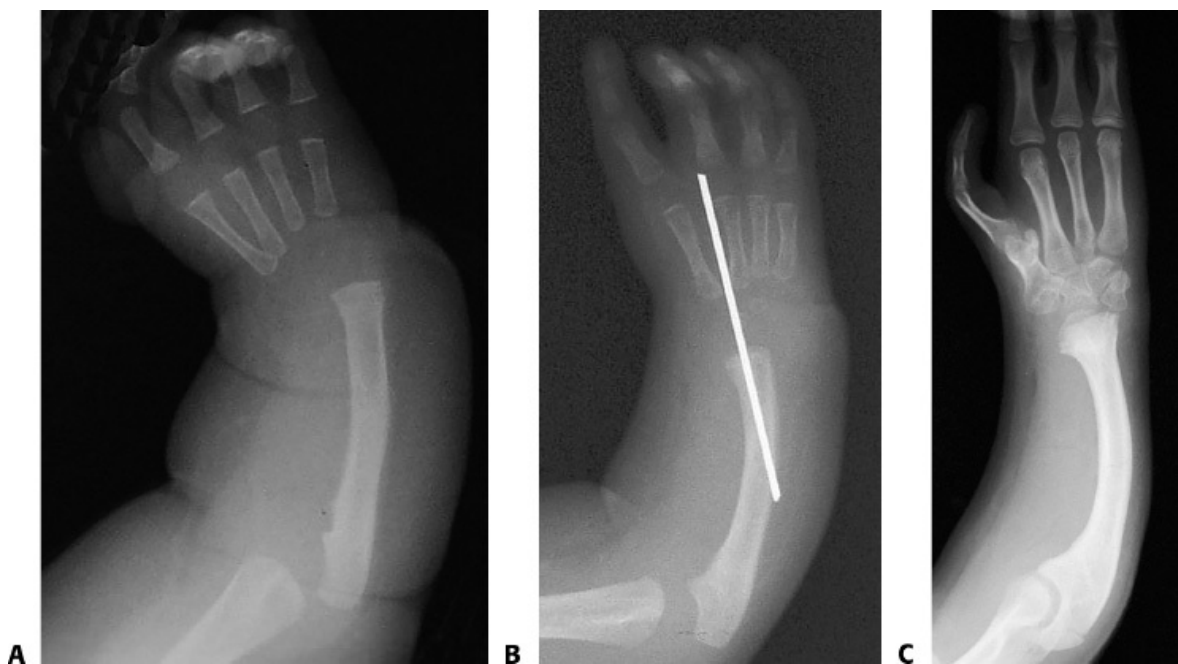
• Long-term result after centralization. A. Initial radiograph showing type IV RLD. After centralization and 12 weeks of pin fixation (B) and 14 years later (C). At long-term follow-up, the wrist maintained adequate alignment. This child was compliant with nightly splint use. Note the index finger has been pollicized.
